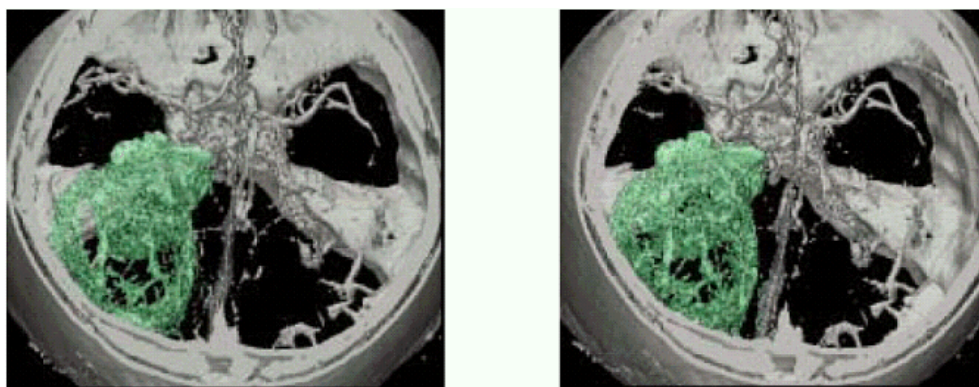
Image pair reconstructed from CT slice of a brain with tumor. Stereoscopic viewing can clearly show the 3D view of the tumor and the surrounding structures (©IEEE).
